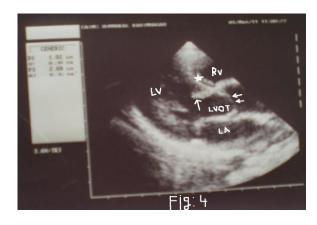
Parasternal long axis view shows a small, thick, fibro muscular ridge (single arrow) just below aortic valve and it is attached to inter ventricular septum (Star). Systolic doming of Aortic Valve Leaflets (paired arrows). (LV-Left Ventricle, LA- Left Atrium, LVOT- Left Ventricular Outflow Tract, RV – Right ventricle).
